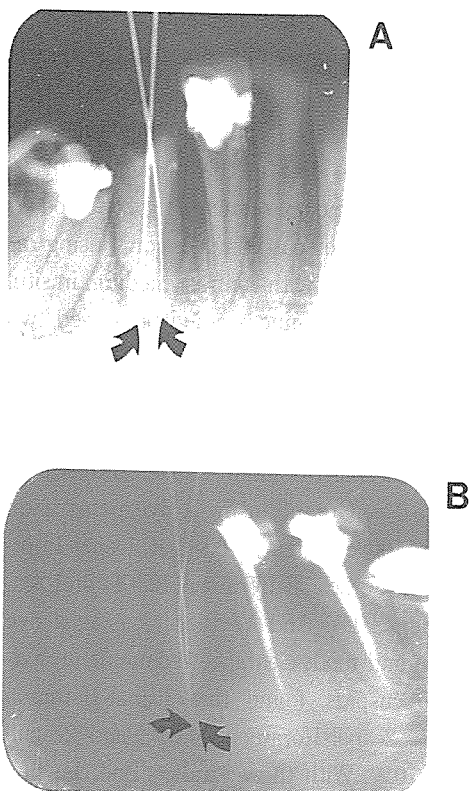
A, Radiograph of right mandibular cuspid taken from a mesial angle with instruments in place shows two different root canals contained in two different roots (arrows). B, Left mandibular cuspid shows two different root apices(arrows).
